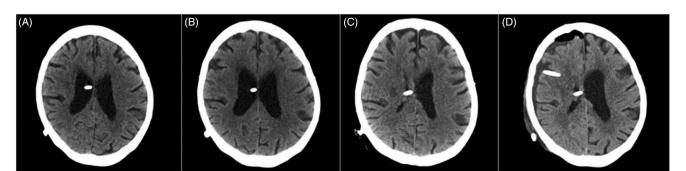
Timeline of axial computed tomography scans. (A) Patient's CT 2 years prior while asymptomatic. (B) CT taken upon presentation to outside hospital (7 weeks prior to admission). (C) CT performed following opening pressure adjustment (1 week prior to admission). (D) CT performed following shunt revision with Y connector placement.
